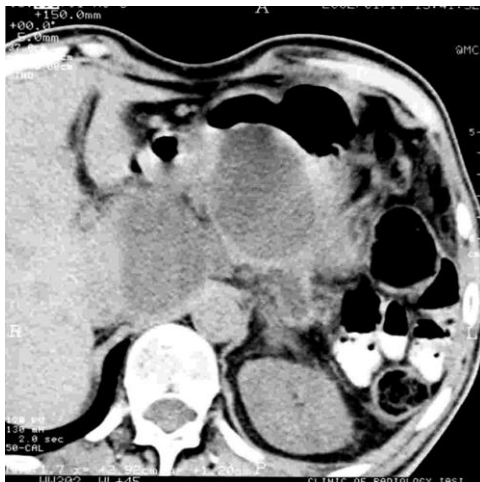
Abdominal CT 11 days after PD: perianastomotic fluid collections suggestive for pancreatic fistula.
